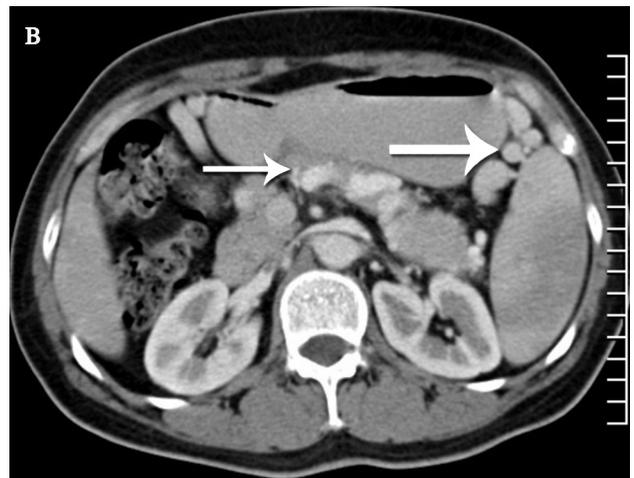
Enhanced CT on hepatic artery phase shows a slightly heterogeneously enhanced tumor in the body and tail of the pancreas.
